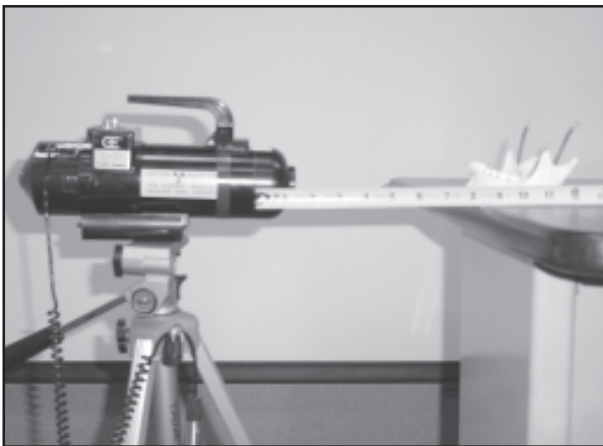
XR-150™ portable x-ray unit mounted on a tripod
